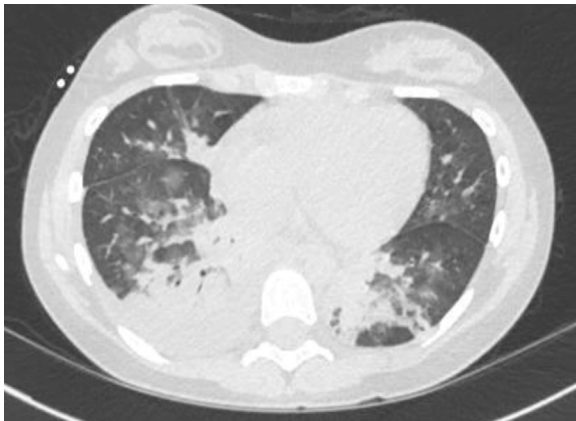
CT of the chest showing bibasilar patchy ground glass opacities, a right lower lobe consolidation, and a right pleural effusion. The patchy lower-lobe ground glass appearance is typical of coronavirus disease 2019 seen in adults.
